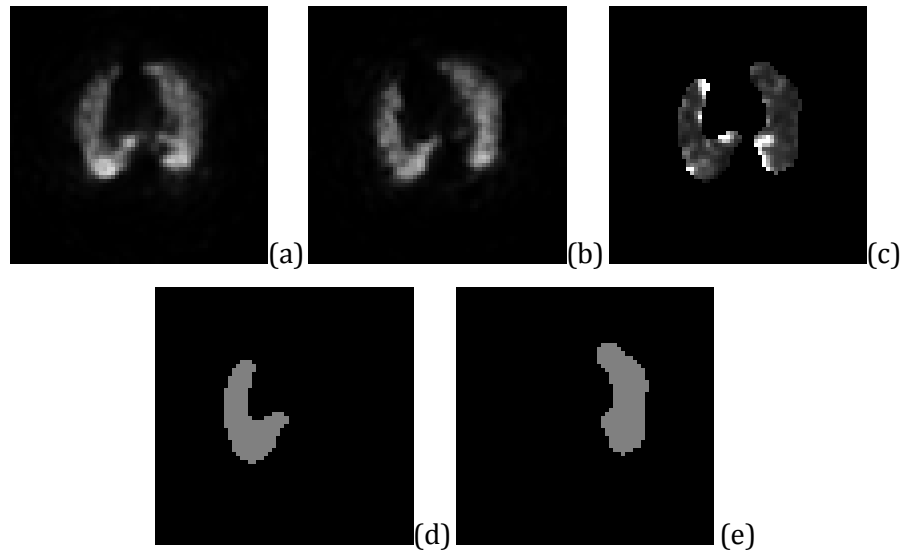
Patient A SPECT images of the same slice: (a) ventilation SPECT; (b) perfusion SPECT; (c) quotient SPECT; (d) binary image of right lung; and (e) binary image of left lung
